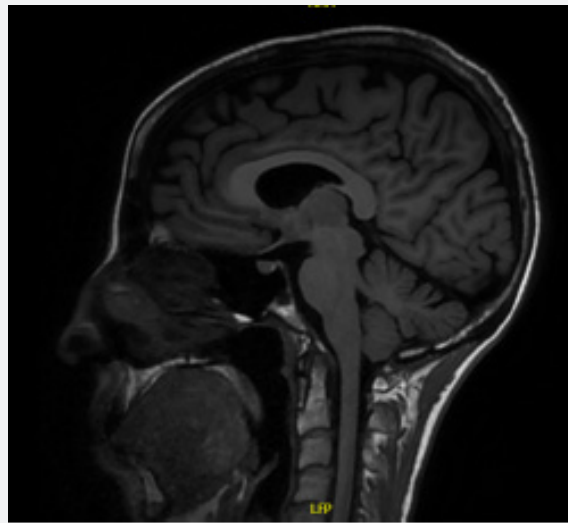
Cranial MRI in T1 sequence performed at 20 weeks of gestation showing permeable ventricular system and venous sinuses, mild right tonsillar ectopia, minimal ventricular asymmetry, slightly enlarged left Meckel's cave, and inversion of cervical lordosis, possibly postural, without significant abnormalities or evidence of intracranial hypertension.
